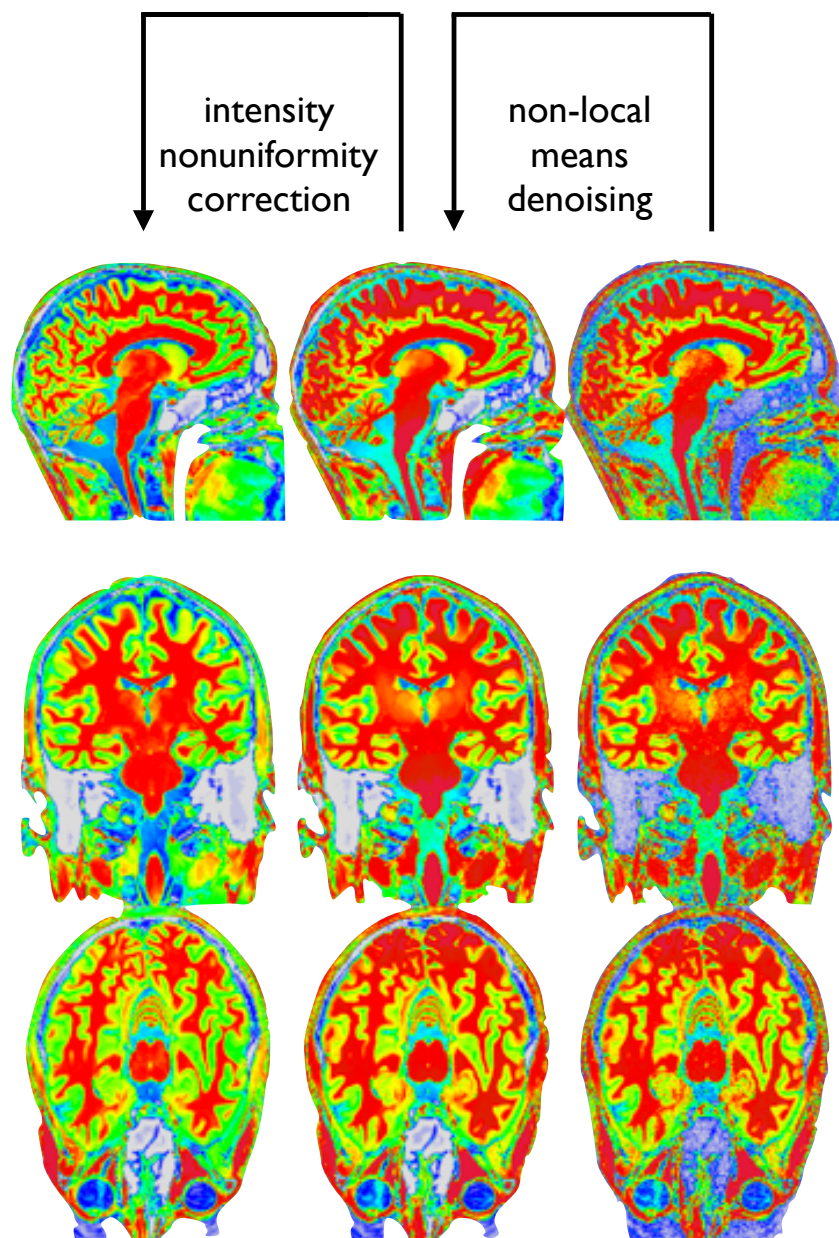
Effects of non-local means de-noising and bias-field correction are depicted for three sections of a T1 weighted anatomical MRI image.
